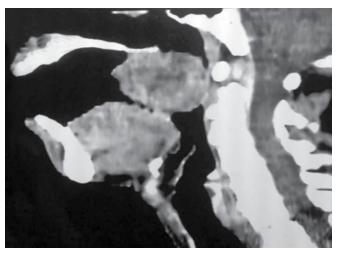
Computed tomography scan of neck with sagittal view showing mass
